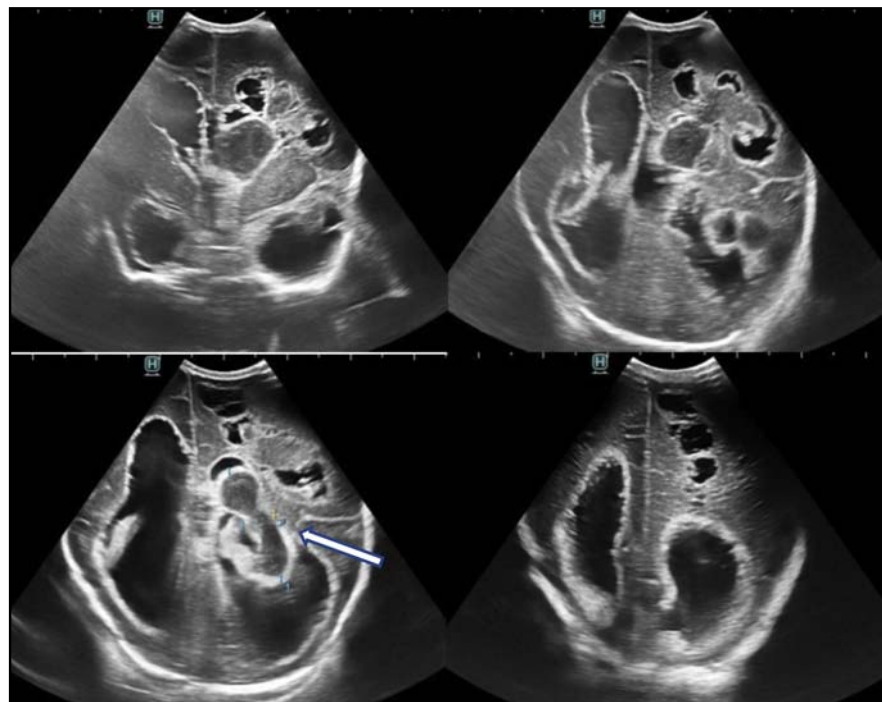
Neurosonographic postnatal examination on the 8th day after delivery, frontal sections of the right and left lateral ventricles, with a marked hyperechogenic rim, with coagulum and numerous porencephalic cysts in the left hemisphere
